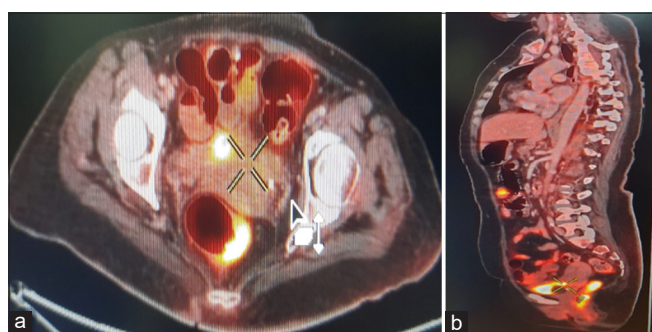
(a and b) Response evaluation PET CT scan post 6 cycles of chemotherapy s/o significant treatment response showing interval metabolic and morphologic regression of lower uterine body and cervix lesion
